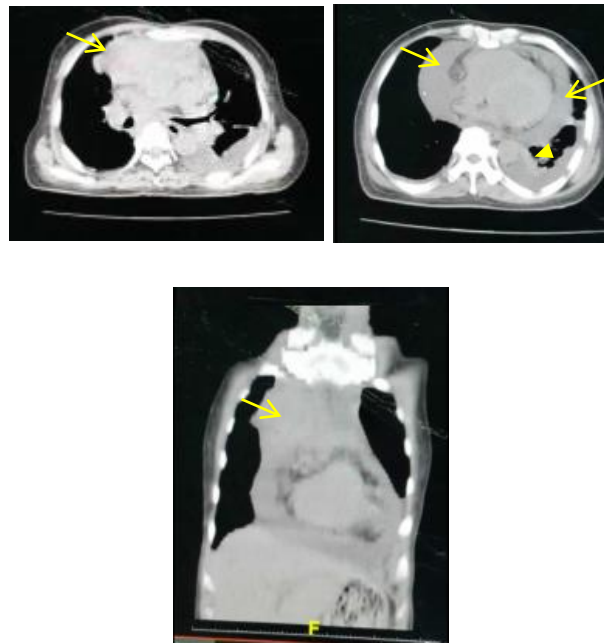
Non contrast chest CT-scan of the patient. A. Mediastinal mass on transversal section (arrow). B. Pericardial effusion (arrow) and pleural effusion (arrow head) on transversal section. C. Mediastinal mass on sagittal section (arrow).
